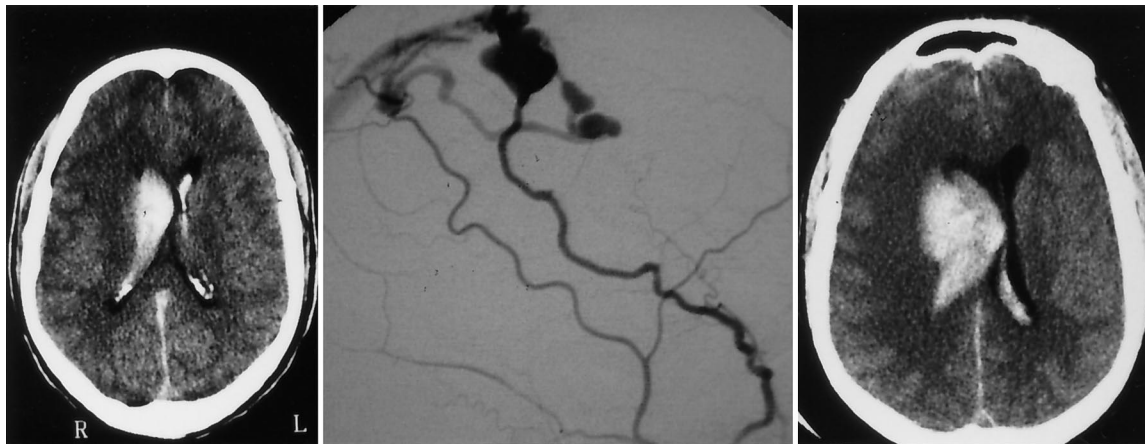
Case 2. *Left:* Admission CT scan obtained after the patient presented with acute headache, transitory loss of consciousness, and left-sided hemiplegia, showing a right frontal hematoma with intraventricular rupture. *Center:* Angiographic study revealing a frontal AVF fed by both middle meningeal arteries, with ectatic cortical venous drainage toward the SSS (Type IV). *Right:* Repeated CT scan obtained 48 hours later, after neurological deterioration and acute coma, demonstrating rebleeding.
